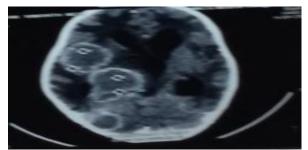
Multiple tuberculoma on CT scan brain
